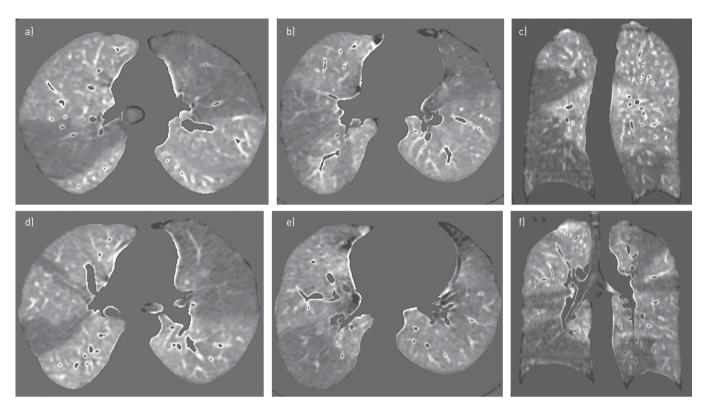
Images show dual-source dual-energy CT lung perfusion imaging in a 51-year-old woman with chronic thromboembolic pulmonary hypertension (CTEPH). a-d) Transverse CT sections and e and f) coronal reformations of dual-energy CT lung perfusion images (window settings: 400 HU/40 HU) show multiple triangular perfusion defects of variable extent in both lungs, highly suggestive of pulmonary thromboembolic disease.
